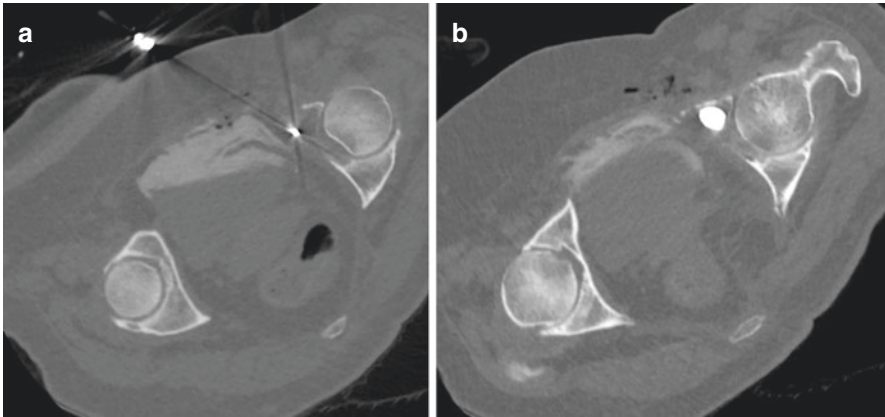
Axial CT imaging demonstrates pre (a) and post (b) radiofrequency ablation and cementoplasty of a left acetabular renal cell carcinoma metastasis with pathological fracture and severe pain. Prior to the ablation, 5% dextrose solution with iodinated contrast was injected medial to the hip to displace the pelvic organs including bladder, and neurovascular structures, as well as into the hip joint for thermal insulation. Anterior approach has been used to access the lesion with a coaxial needle, through which an ablation probe was passed. Subsequently, bone cement (polymethyl methacrylate, PMMA) was injected for structural support
